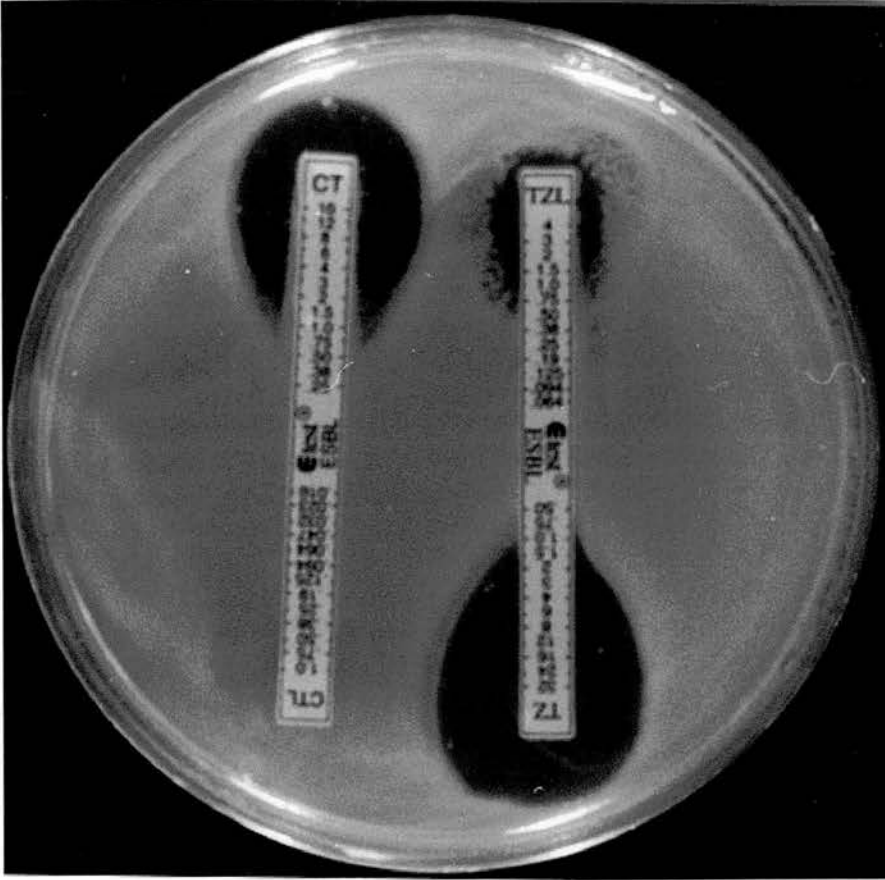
Plate showing negative ESBL reaction with E-test strips containing cefotaxime + cefotaxime/clavulanic acid (CT/CTL) and ceftazidime + ceftazidime/clavulanic acid (TZ/TZL).
